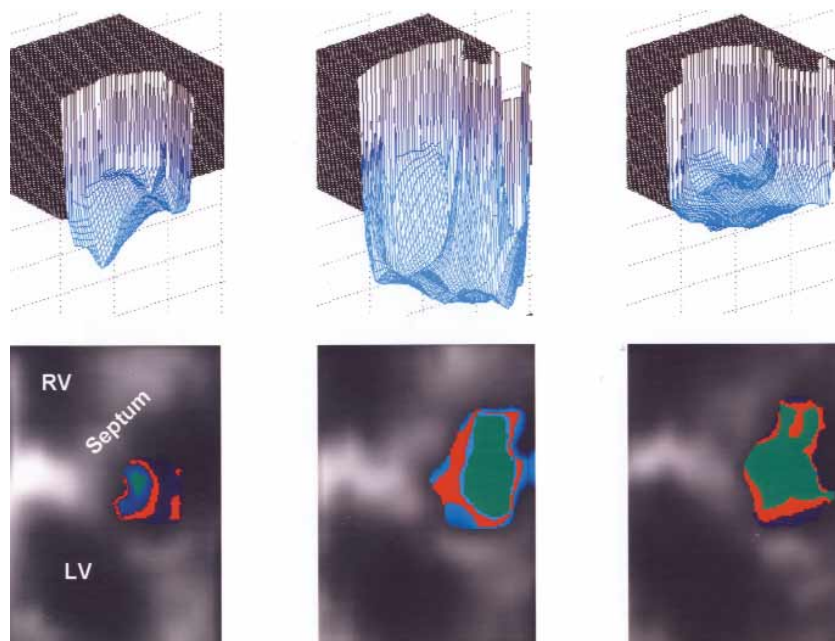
Examples of 3-dimensional velocity profiles from early systole, peak flow, and late systole. Profiles are visualized as mesh plot and encoded as color flow Doppler in 2-dimensional slices extracted from 3-dimensional data. Height of mesh plot is proportional to blood flow velocities. Corresponding 2-dimensional slice is located below each mesh. *Green*, Maximum velocity; *Red*, mean velocity; *LV*, left ventricle; *RV*, right ventricle.
